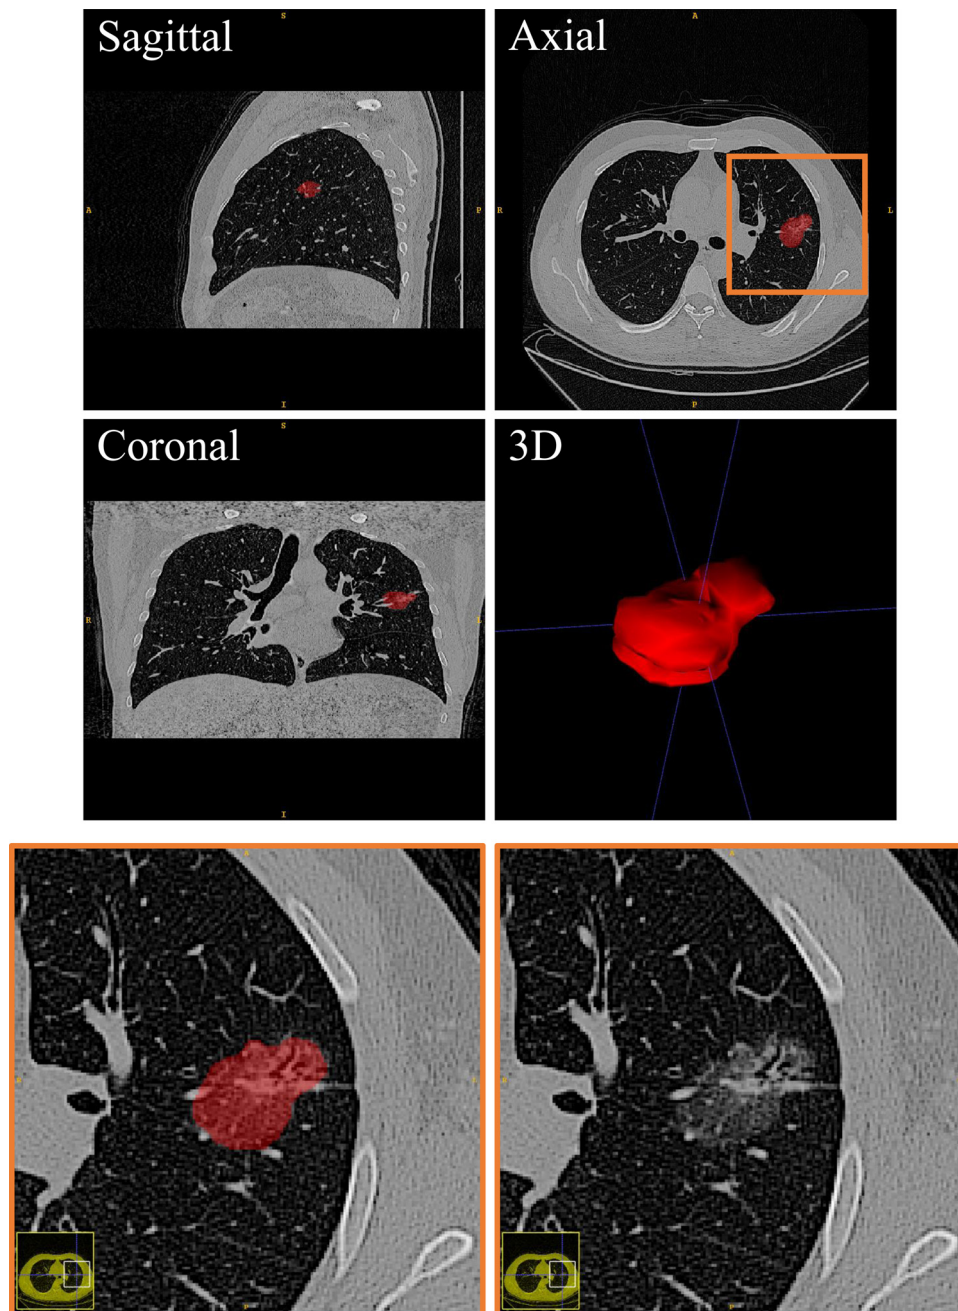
Region of interest (ROI) for the ground glass opacifications on computed tomography scans.
